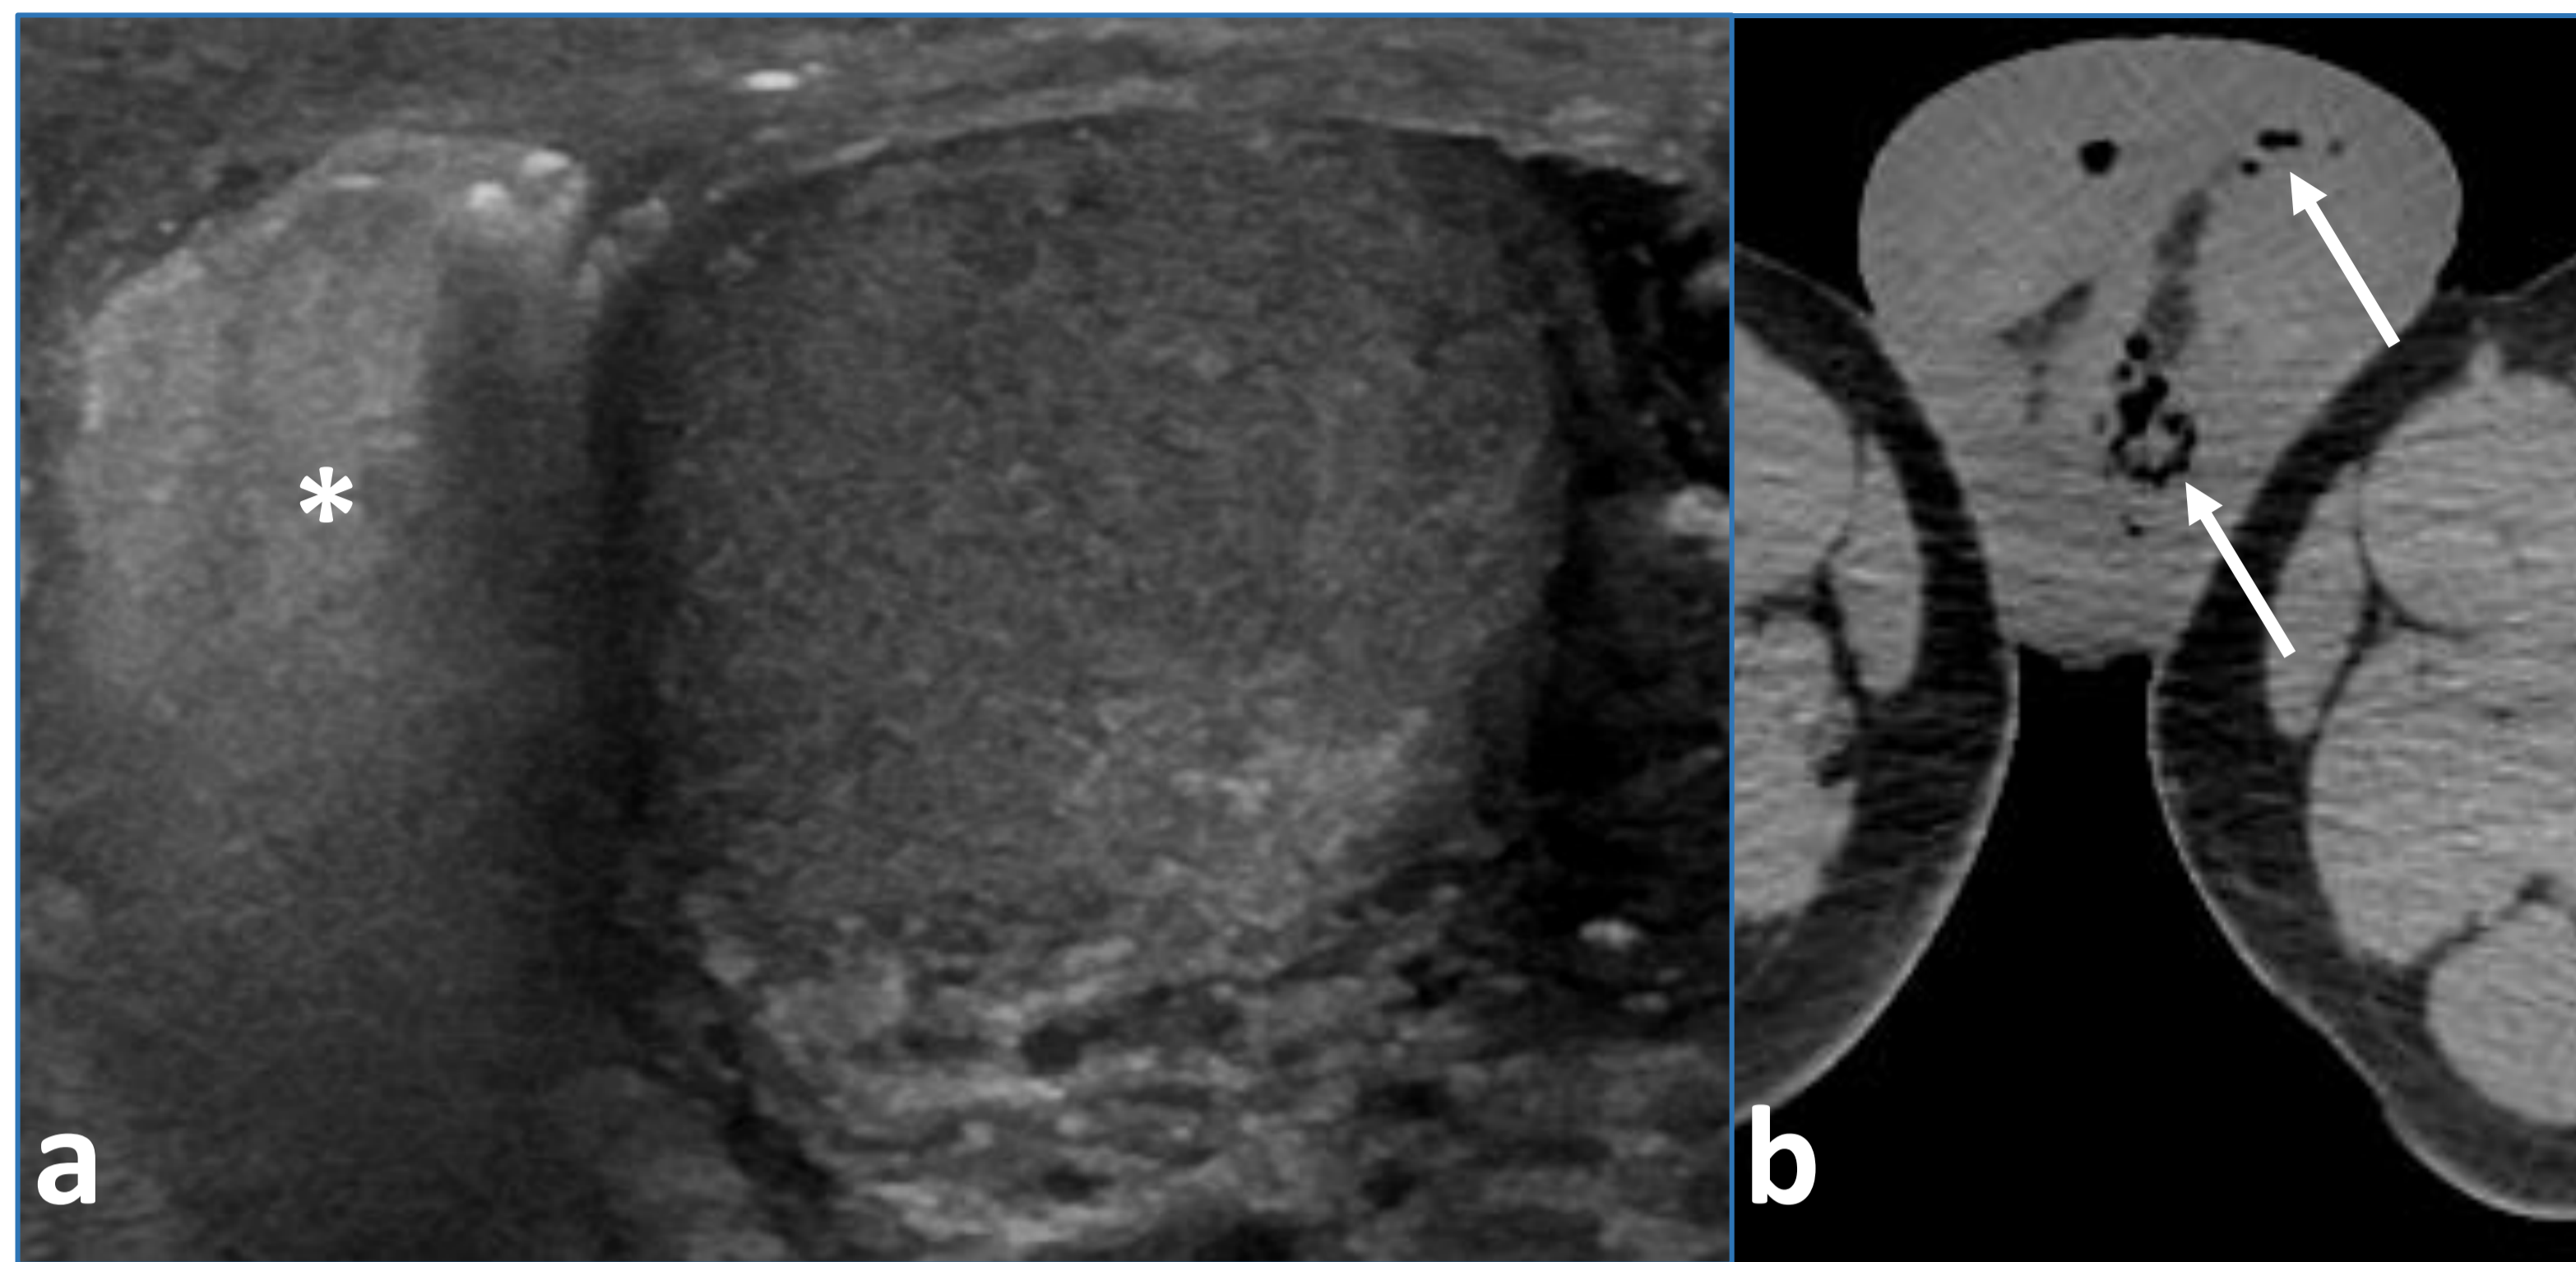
Fournier's gangrene with scrotal involvement. a. US image shows scrotal wall edema with soft tissue gas (*). b axial CT image confirms US findings of bilateral scrotal edema and soft tissue gas (arrow).
